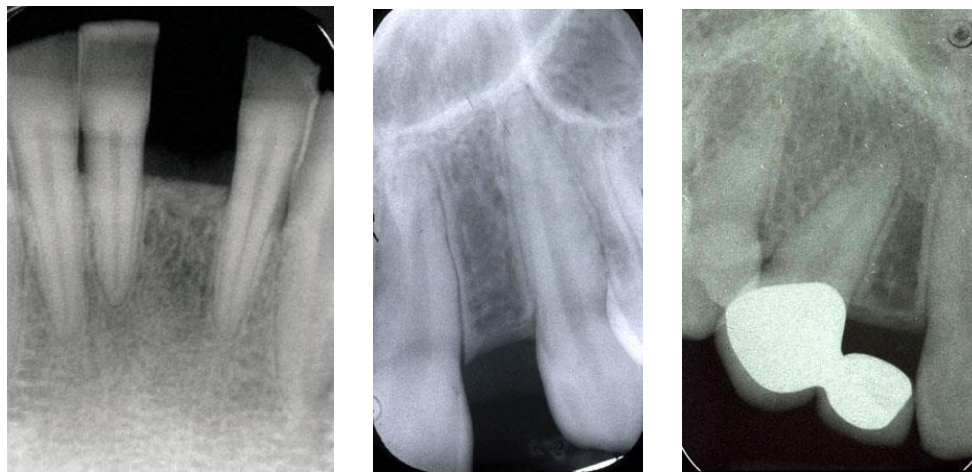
periapical radiograph
